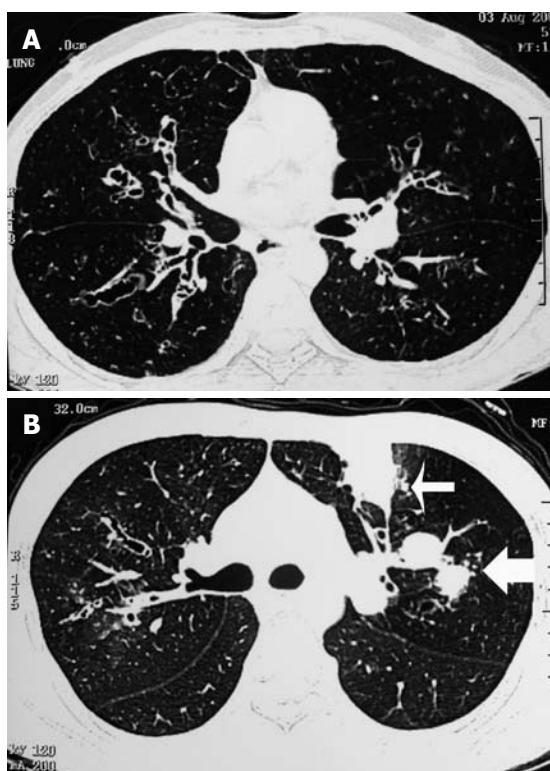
High-resolution computed tomography of the chest from two different patients showing typical central bronchiectasis (panel A). Mucus plugging within dilated bronchi (bronchoceles, thick arrow) and subsegmental atelectasis (thin arrow) are other common findings (panel B).
